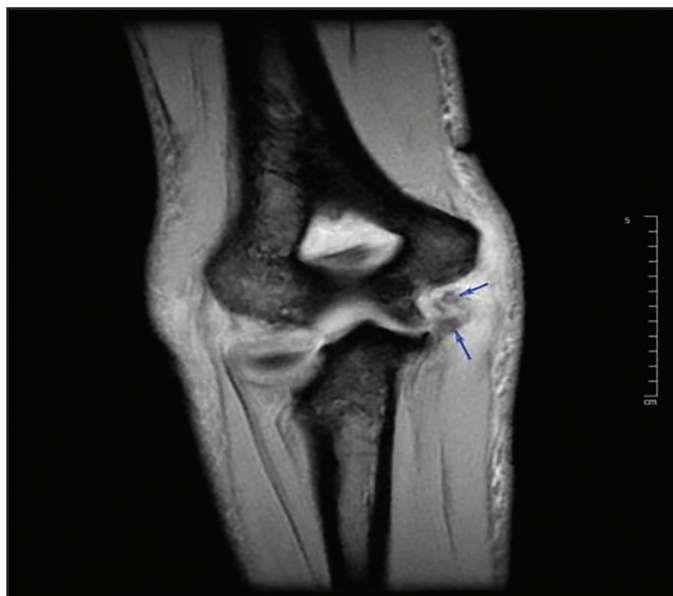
T1 Magnetic Resonance Imaging (MRI) with report which revealed a complete UCL tear (blue arrows) 2) Partial-thickness common flexor tendon tear, 3) Possible radial head buckle fracture with radial neck and lateral humeral condyle contusion injuries, 4) Low-grade partial-thickness tears of the pronator teres and flexor digitorum superficialis.
